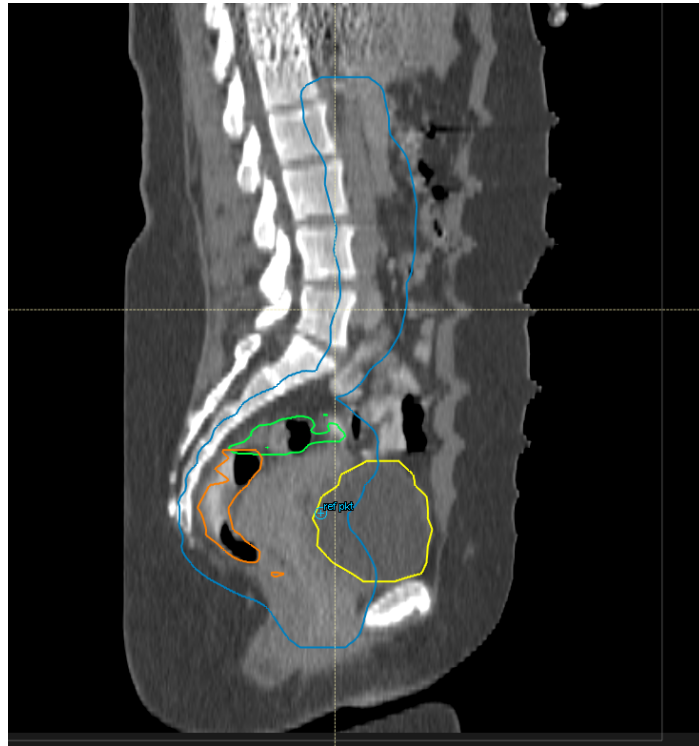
Sagittal plane CT view of a patient included in this study, along with delineated clinical structures. The blue structure is the combined planning target volume (PTV) for both main pelvic and elective targets (PTV-T + PTV-E). The green structure is the sigmoideum, the orange structure is the rectum (including the anal canal) and the yellow structure is the bladder. The image is taken from the RayStation treatment planning system.
